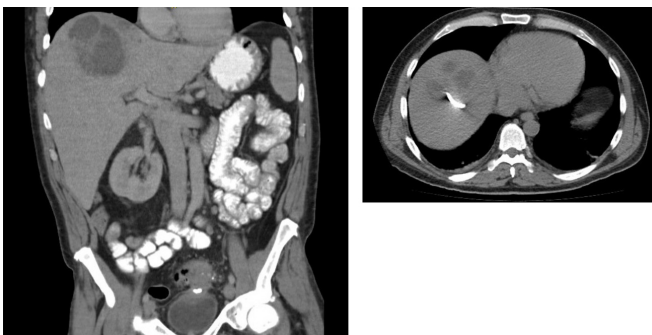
Computed tomography images of a 54-year-old male with prior diverticulitis and liver abscess 2 years ago (treated with percutaneous drainage and antibiotics for 3 months), who presented with a new liver abscess and recurrent diverticulitis. The abscess was drained for 7 days with no change in size. Blood cultures were positive for *E. Coli* and the patient experienced daily intermittent fevers to 103°F (39.4°C). The patient underwent laparoscopic debridement with subsequent resolution of fever. The drain was removed on postoperative day 7, antibiotics were administered for 2 weeks, and the patient returned to work on postoperative day 14.
